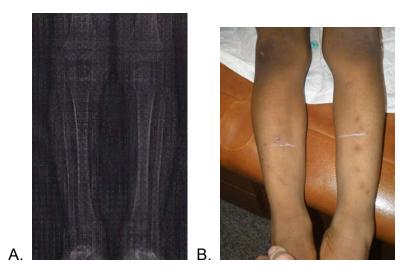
(A) Radiograph of Participant #15 with history per parent of tibial bowing that was thought to be bilateral with possible increase on the right. Bracing was used bilaterally for 6 months and then stopped. (B) Upon our examination we could not see any anterior bowing and only mild bilateral bowing which we thought was likely within normal limits and most consistent with physiologic bowing.
